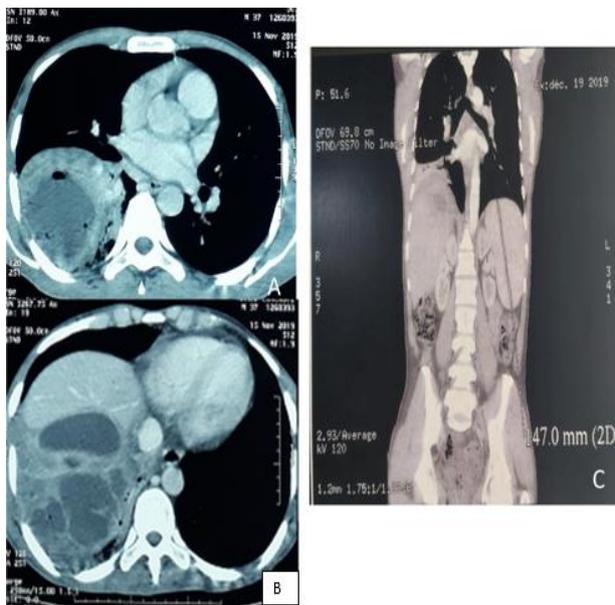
Patient # 3 X-Ray and Endoscopic Iconography: A & B Abdominal chest CT showing fistulised liver hydatid cyst in bile duct and communicating with lung abscess
